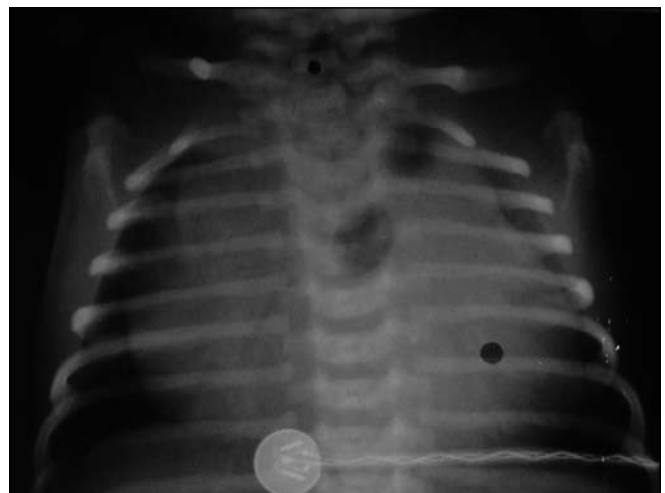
Frontal radiograph of the patient's chest shows massive global cardiomegaly.
